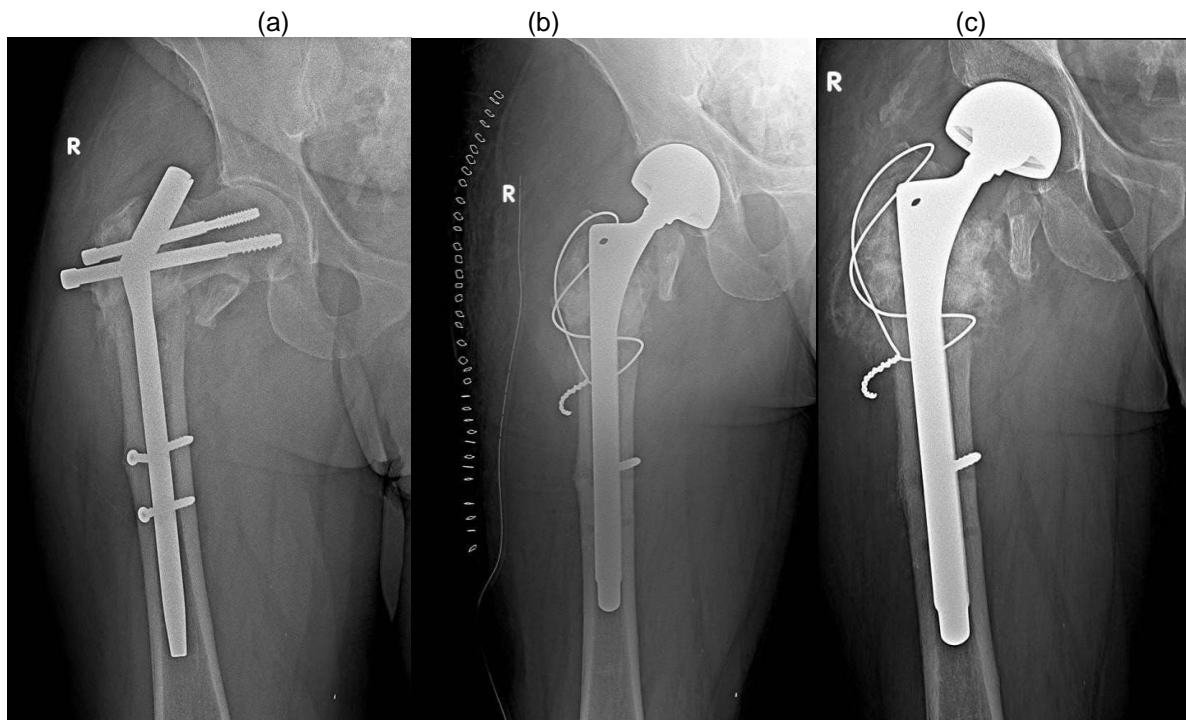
a) radiograph of failed osteosyntheses following PFN, b) immediate post op radiograph after bipolar hemiarthroplasty using distal fitting stem and c) follow up radiograph after 18months
